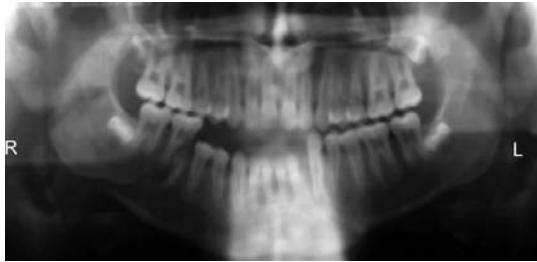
Radiographic view of mandibular right angle fracture
